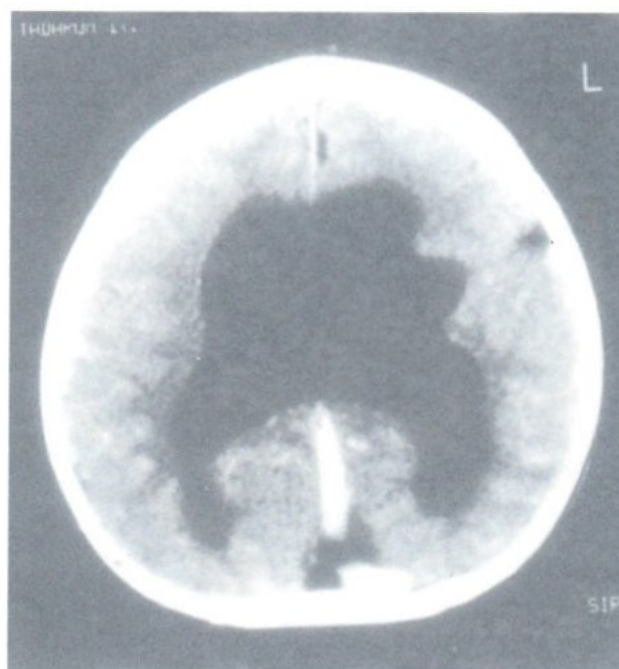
Axial CT brain of a patient with hydranencephaly shows absent septum.
